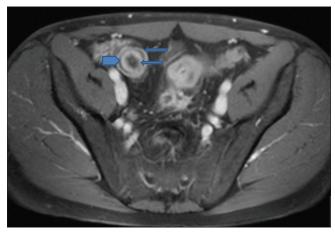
Axial postcontrast T1-weighted image of the abdomen shows the "target" sign or mural stratification with hyperenhancement of the inner mucosa and outer serosa (arrows) and nonenhancing intervening edematous submucosa (arrowheads)
